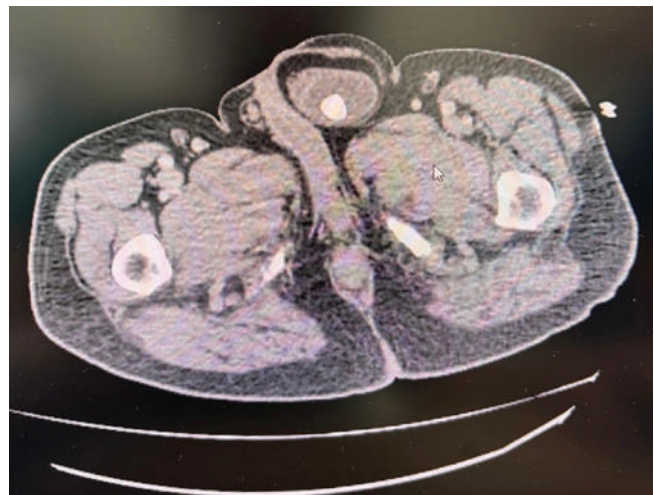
Preoperative abdominal CT. Herniation of the left anterior portion of the bladder into the left inguinal canal on abdominal CT, with a stone-density observed within the bladder lumen.
